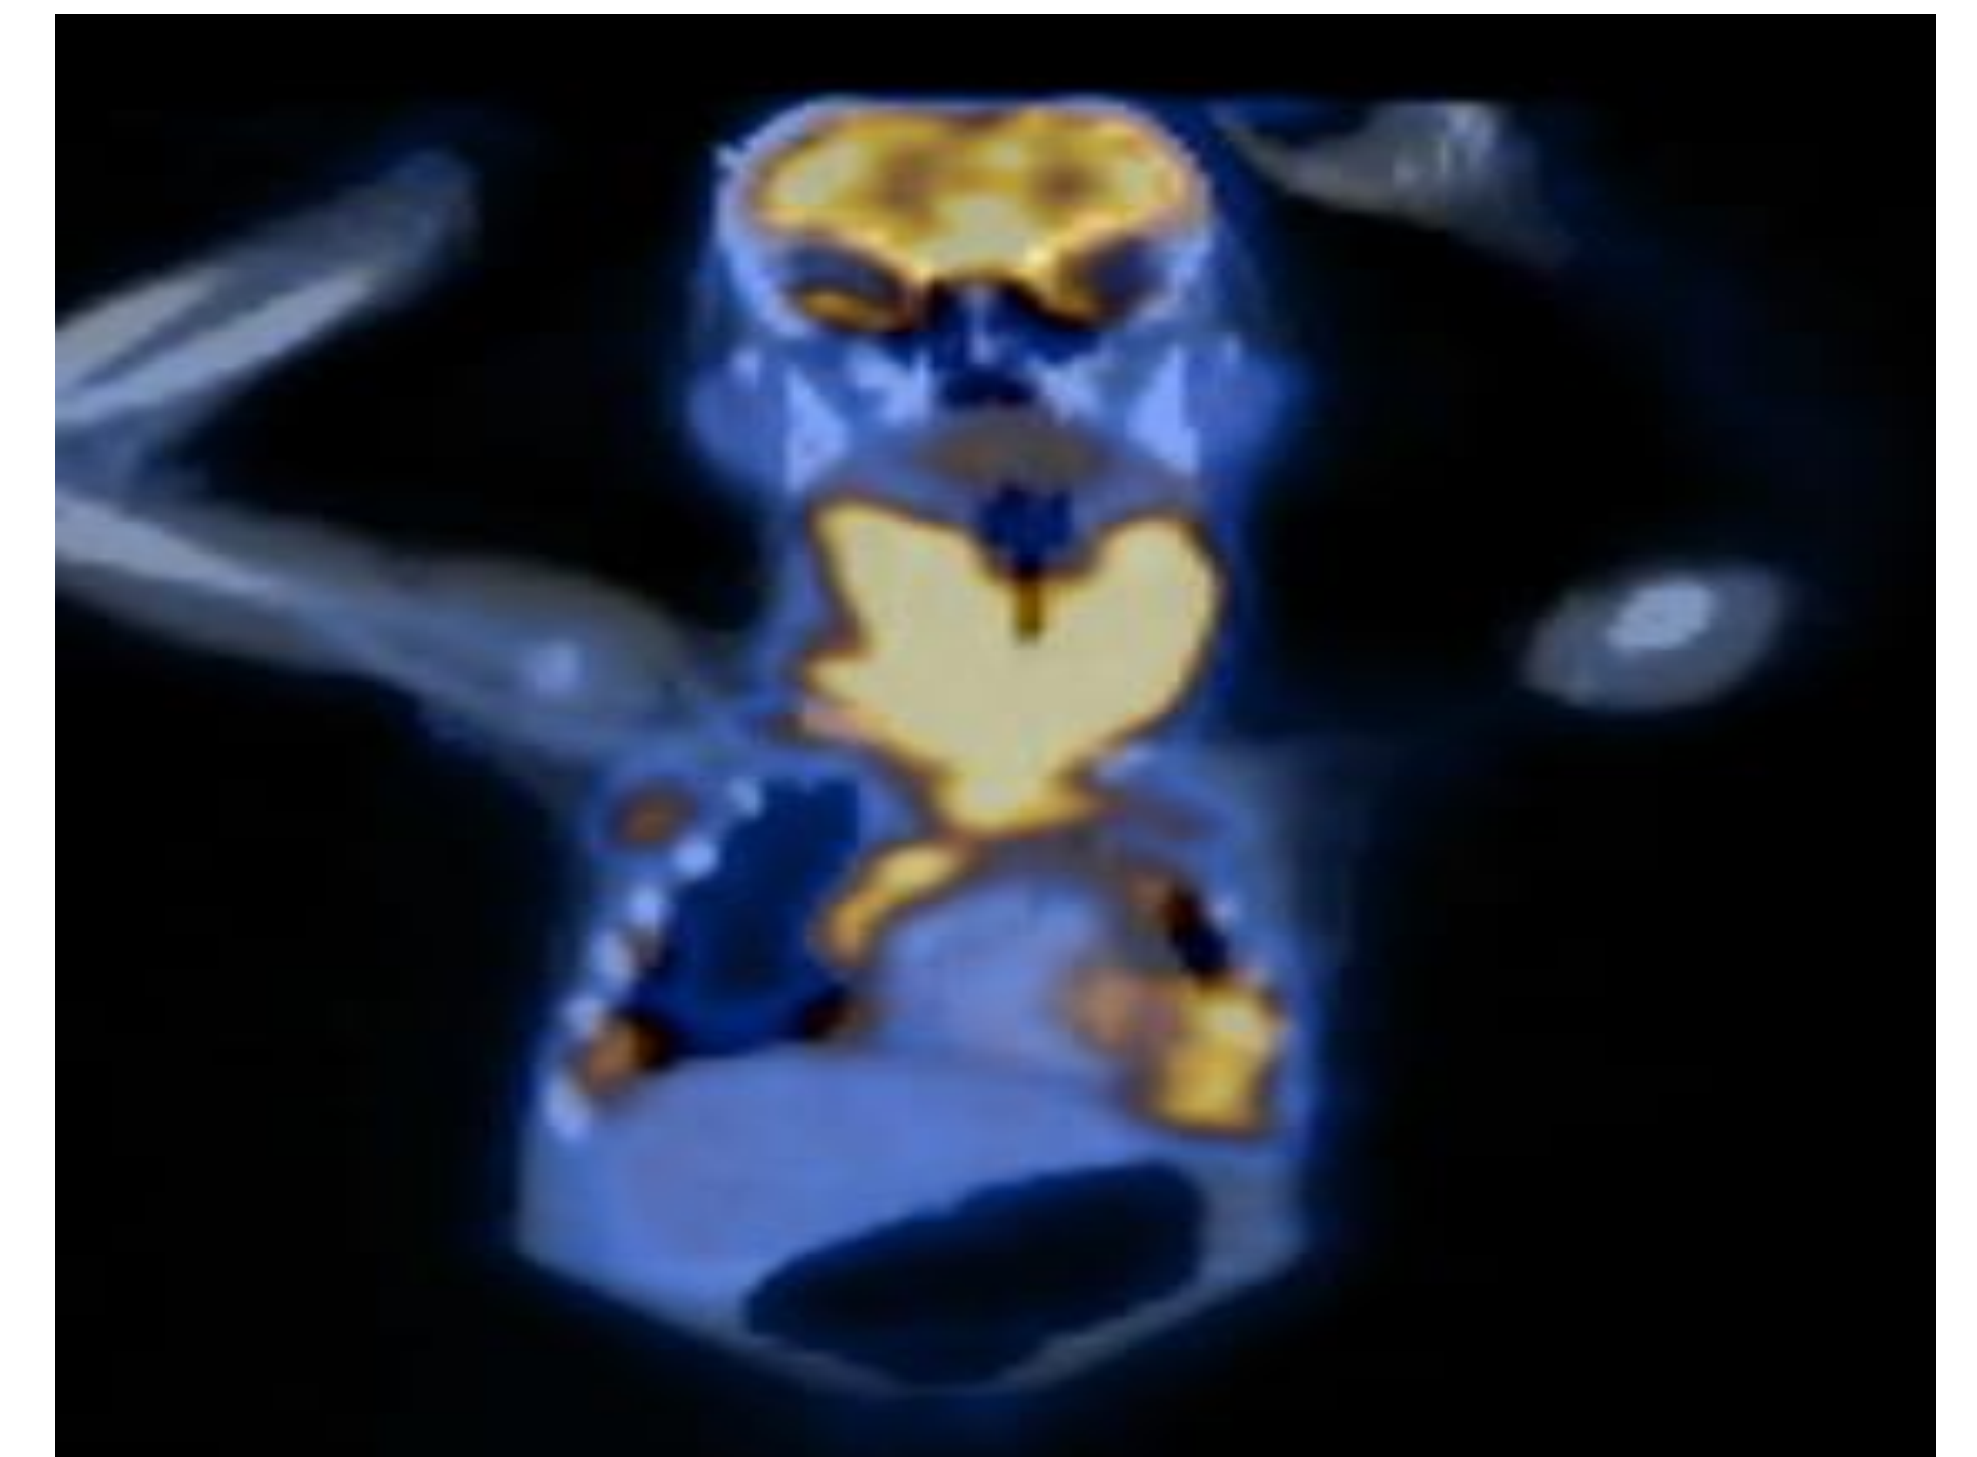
PET- CT demonstrating multiple foci of hypermetabolic abnormalities (scalp, left maxilla, anterior and posterior mediastinum, right axilla and bilaterally pleural spaces)
